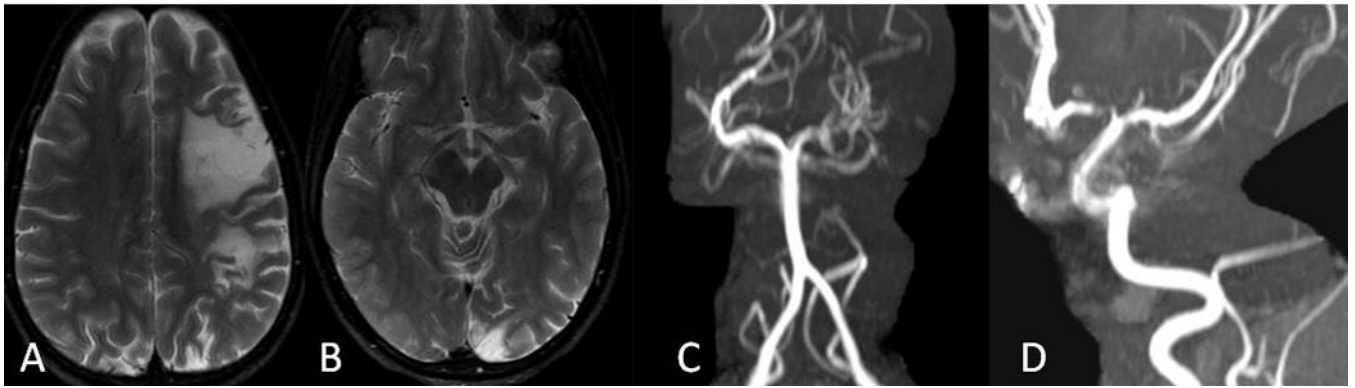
Patient #2. T2-weighted axial image shows left frontal and frontoparietal chronic infarcts (A) which resulted in wallerian degeneration in the left cerebral peduncle (B). An old infarct in the left occipital lobe is also shown on image B. MRA shows significant narrowing of the left PCA (C) and focal stenosis in the left A1 segment and inferior M2 segment (D).
